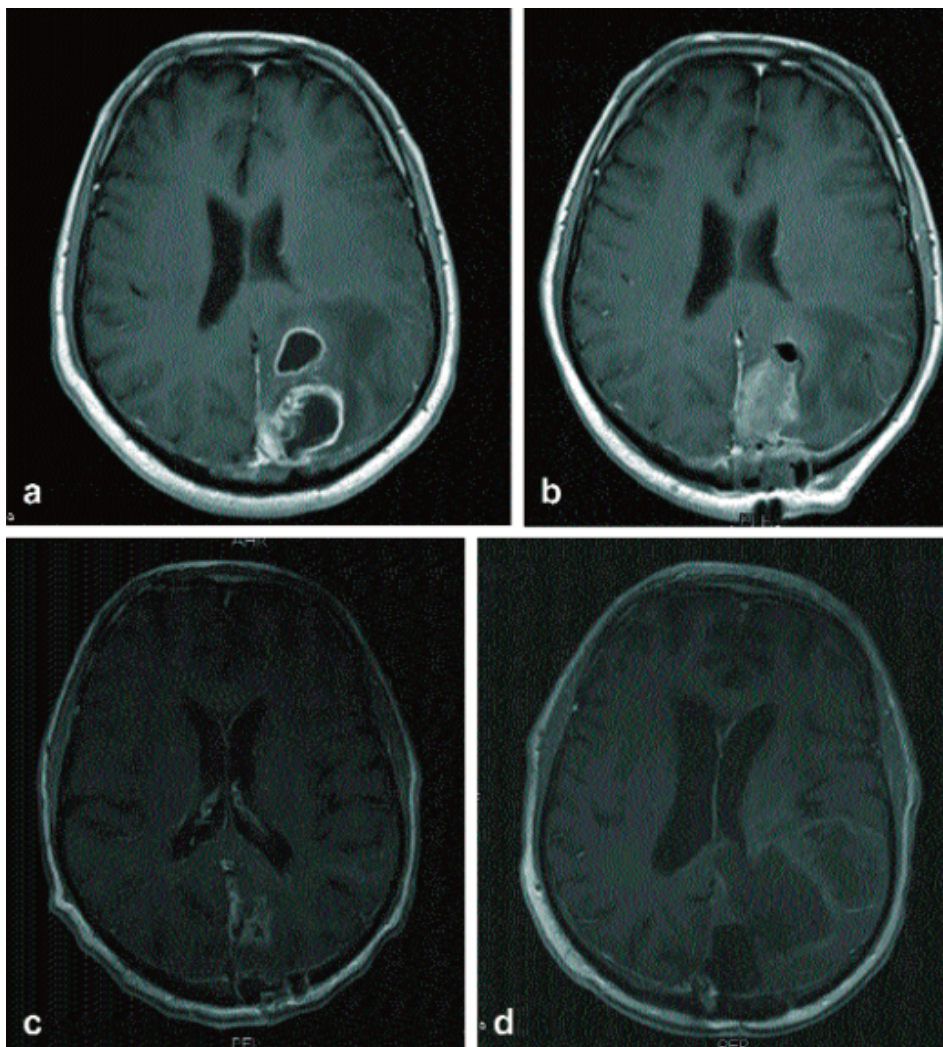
(a-d): MRI Axial T1WI with contrast at 6-months interval showing a left occipital GBM, post-operative scan showing gross total resection, follow up scan showing controlled disease, and the last scan showing extensive parieto-occipital recurrence.
